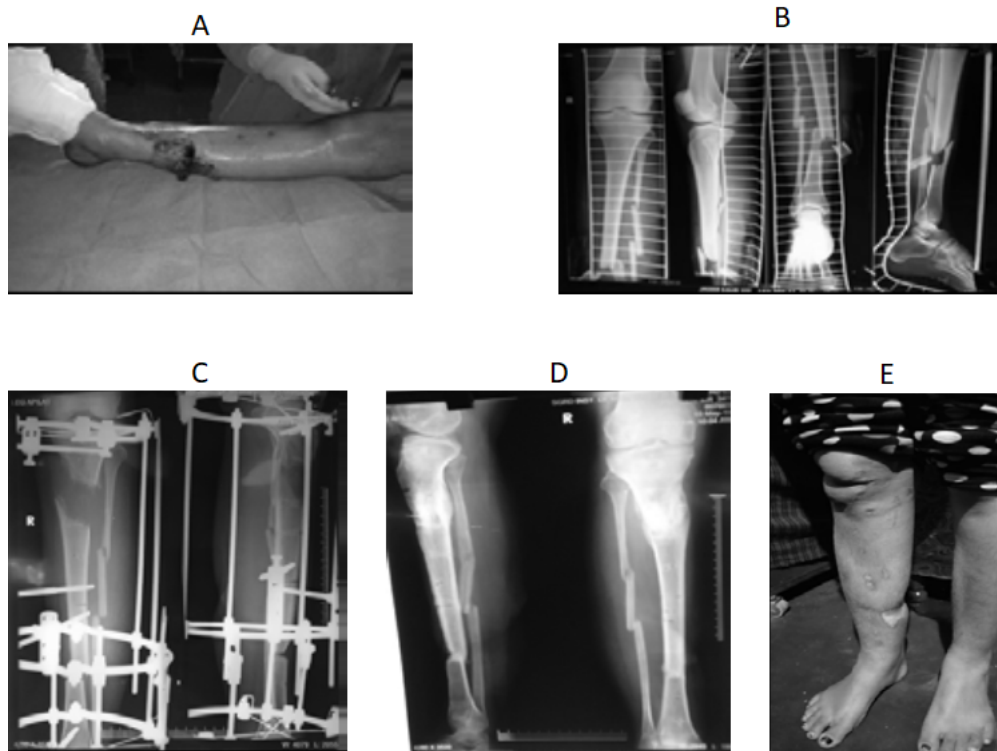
A-Preoperative clinical picture. B-Preoperative X-Ray. C-X-Ray at 6 months. D- X-Ray after removal of fixator at 1 year. E- Clinical picture after removal of fixator.
